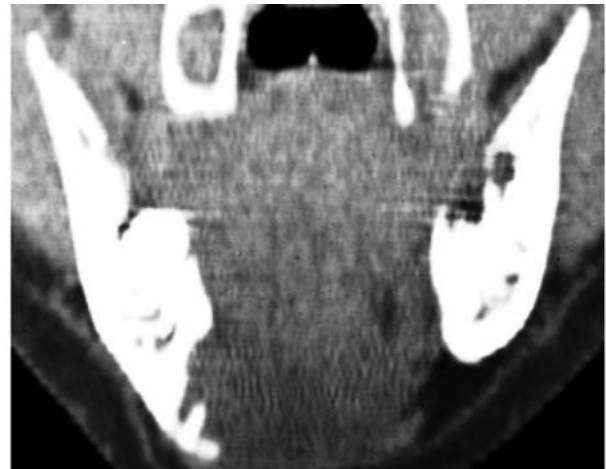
Computed tomography coronal section of the mandible showing a lingual defect with caudal displacement of the bone on the right side.
